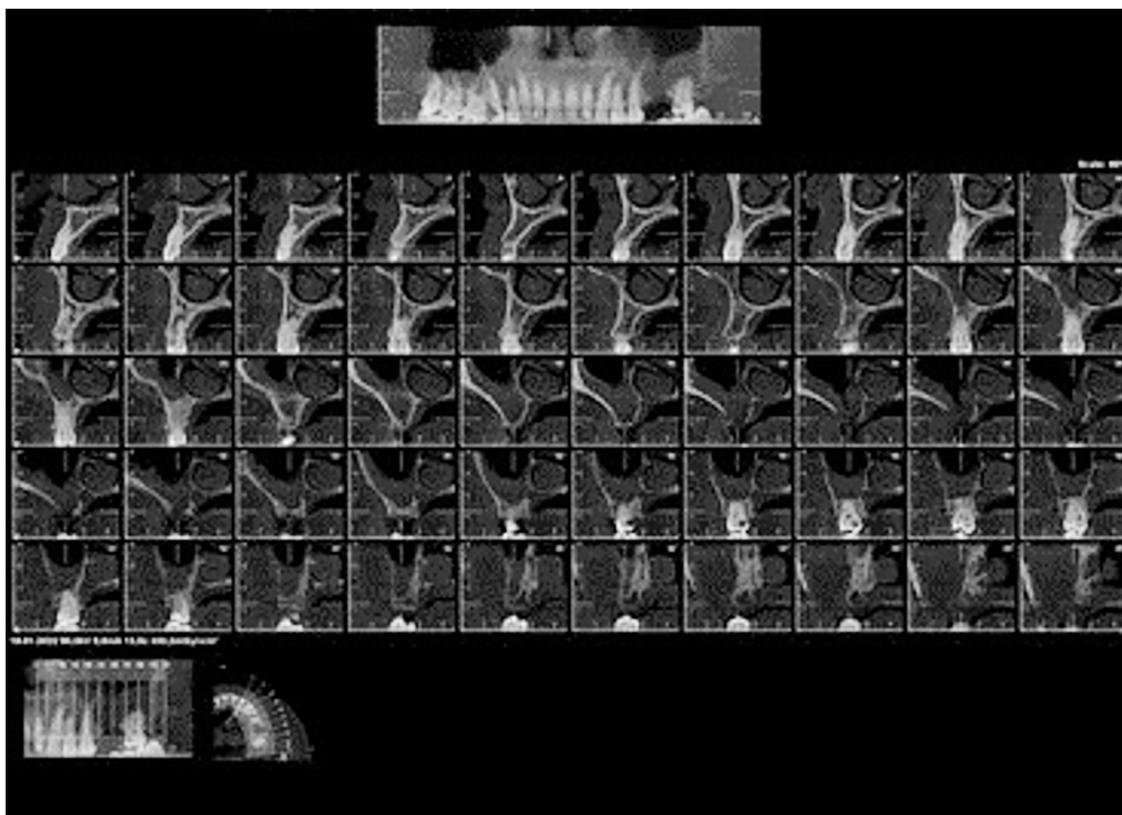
CBCT imaging showing the oroantral fistula and sinus pathology.
